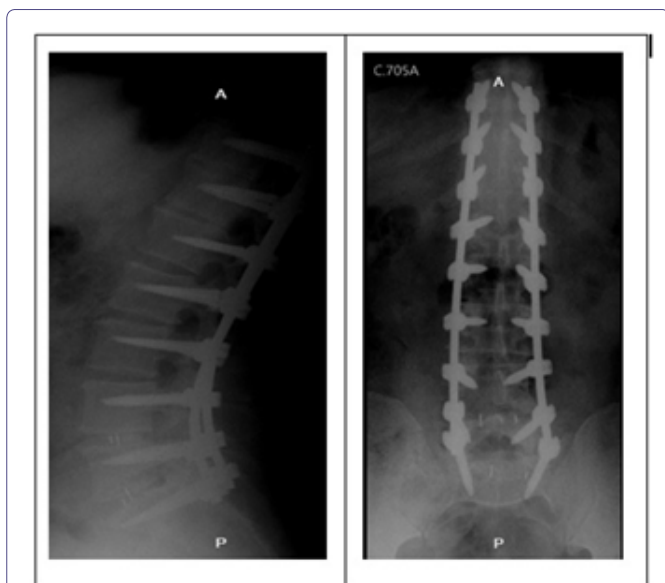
First post-op simple X-rays. Arthrodesis material adequately placed, pedicular screws fixation and intersomatic cages L4-L5 and L5-S1.
